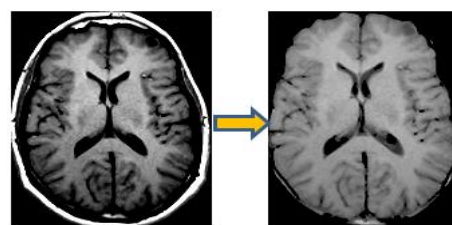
Removing the skull from a slice of an MRI brain image
